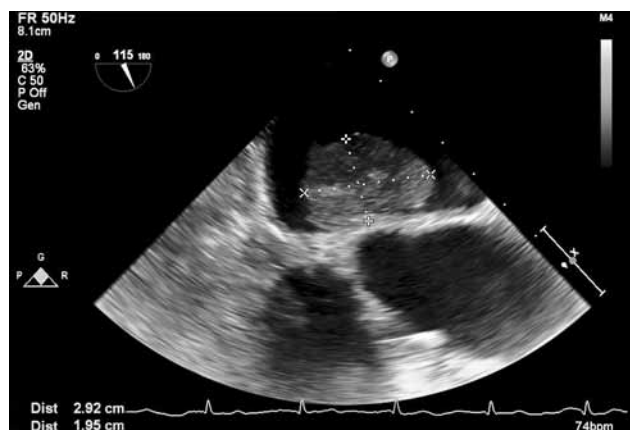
Echocardiographic image of myxoma.
